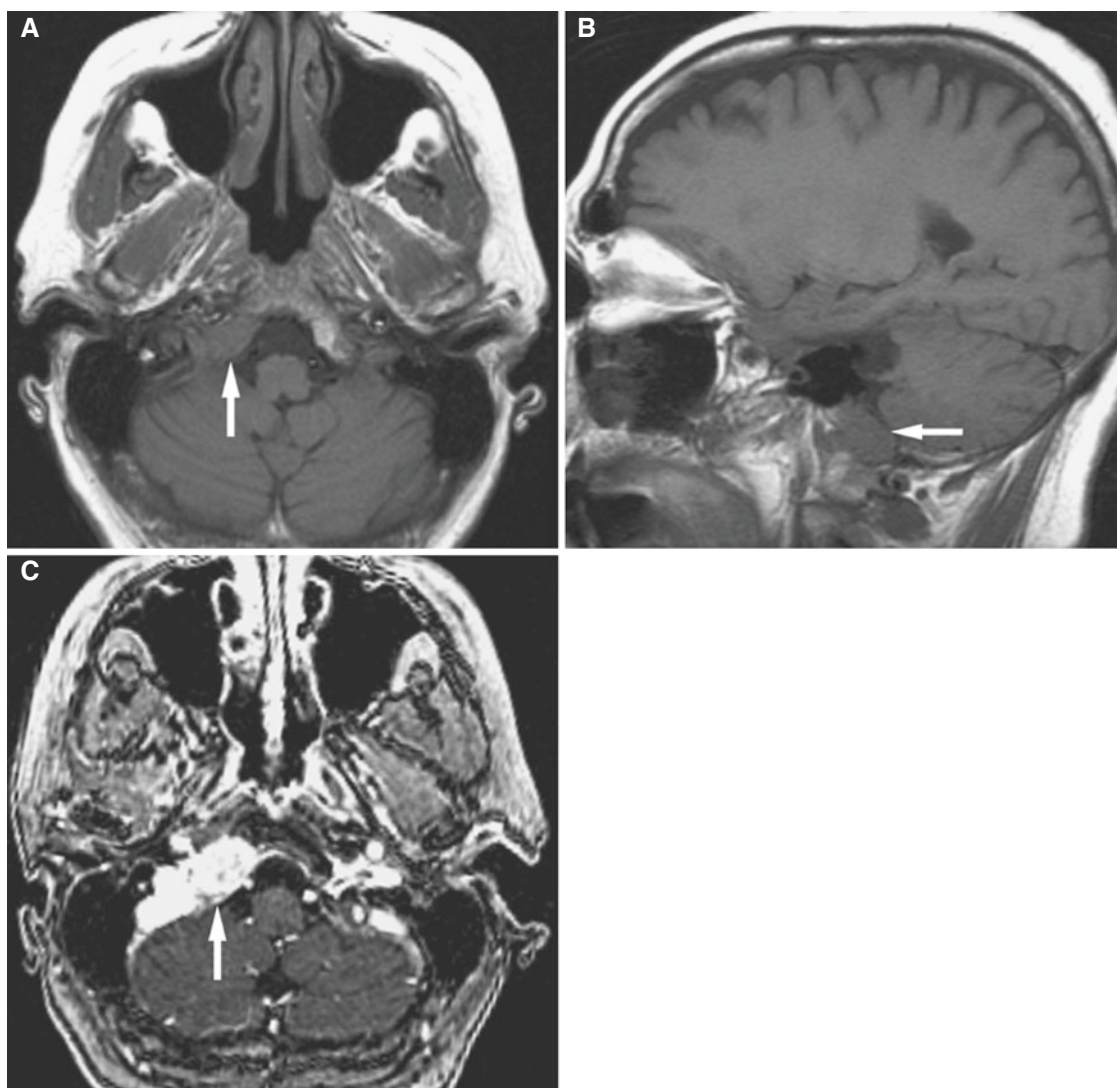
Metastatic disease; 55-year-old female with breast cancer presented with swallowing difficulties. (A) Axial T1-weighted MRI demonstrates well-circumscribed hypointense lesion involving right
